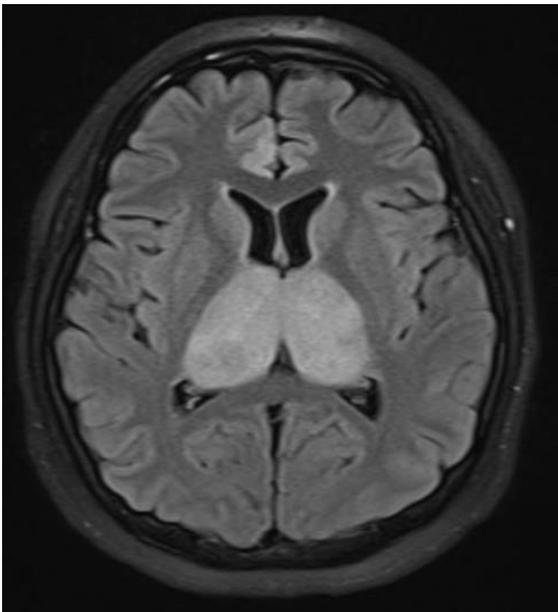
Axial FLAIR sequence shows prominent bilateral hyperintense thalami.
